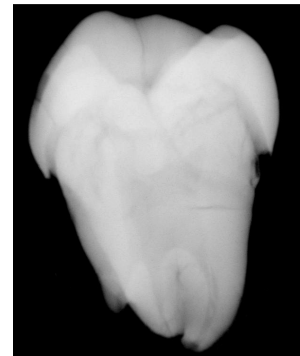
Radiograph (tooth 6 main study, 800°C)
